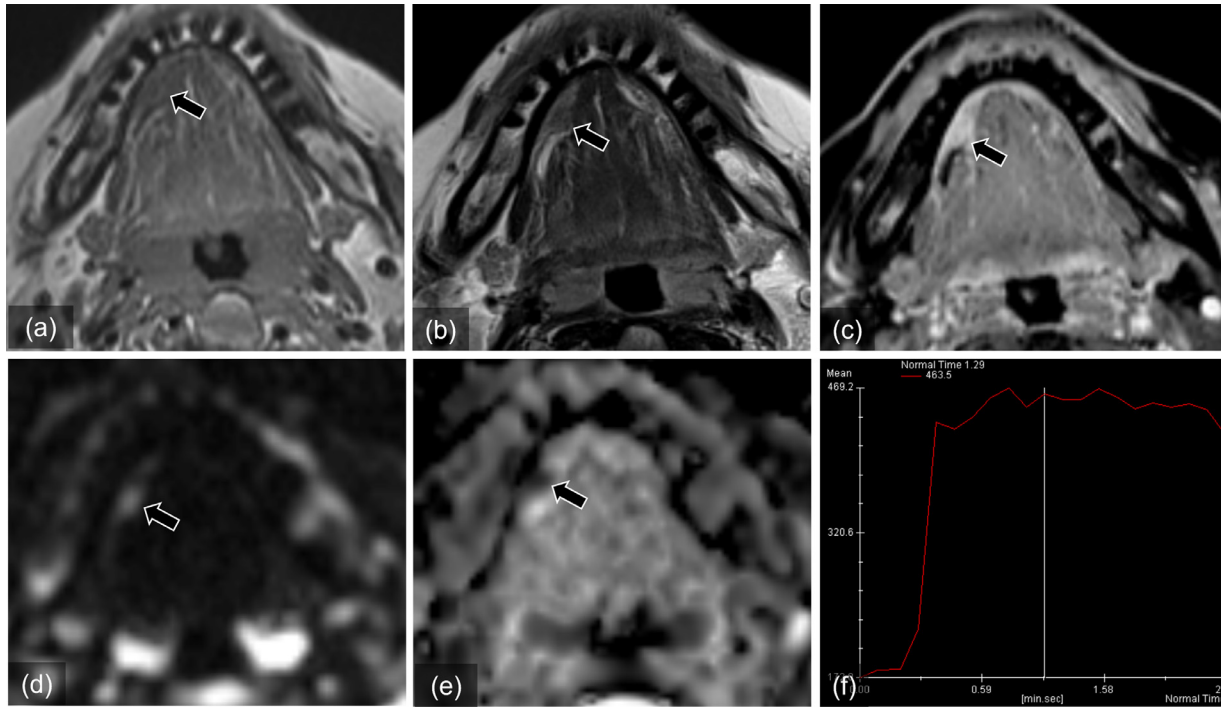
Magnetic resonance images of the mass on the right side of the floor of the mouth. (a) axial T1-weighted image (T1WI), (b) axial T2-weighted image (T2WI), (c) axial contrast-enhanced fat-suppressed T1WI, (d) axial diffusion-weighted image (DWI) ($b = 1000 \text{ s/mm}^2$), (e) apparent diffusion coefficient (ADC) map, (f) time-intensity curve of dynamic contrast-enhanced MRI. The mass shows isointensity relative to the surrounding muscle on T1WI, homogenous hypointensity on T2WI, and restricted diffusion (a, b, d, e, arrows). The time-intensity curve shows a rapid initial enhancement before reaching a plateau. (f) The mass shows uniform, slightly stronger enhancement than the normal sublingual gland (c, arrow).
